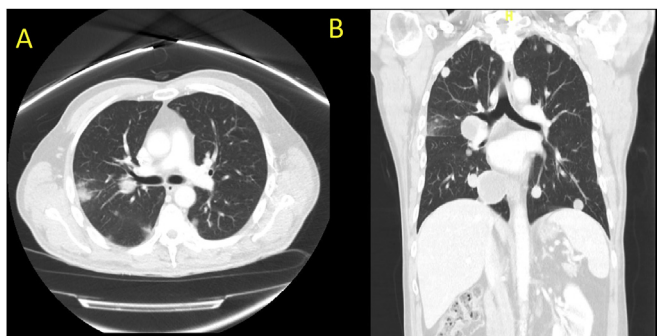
Computerized tomography (CT) scan of the chest 6 months before presenting with hemoptysis. Axial (A) and sagittal (B) views shows multiple pulmonary nodules and masses of different size compatible with pulmonary metastases.
